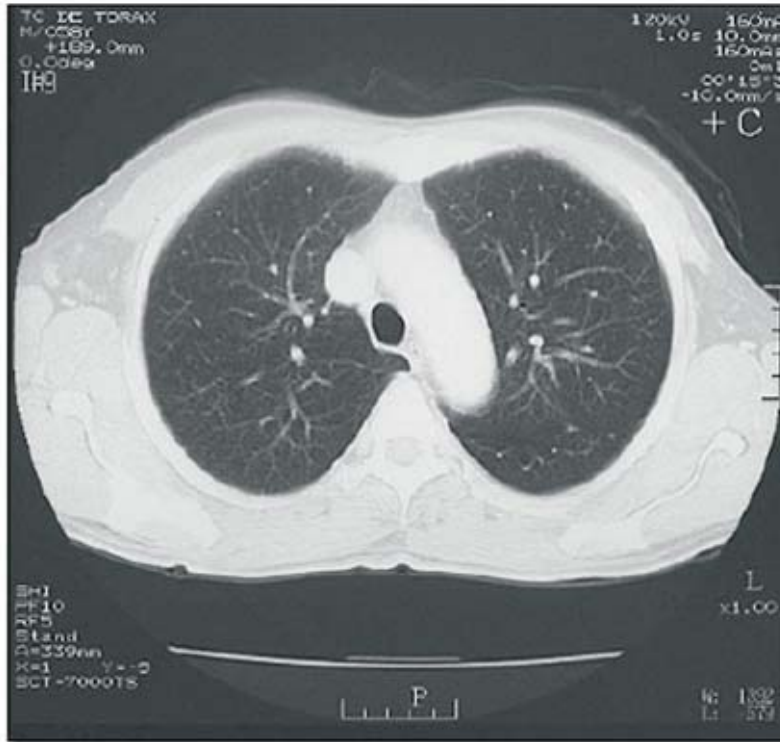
Computed tomographic image of the middle portion of the lungs.
